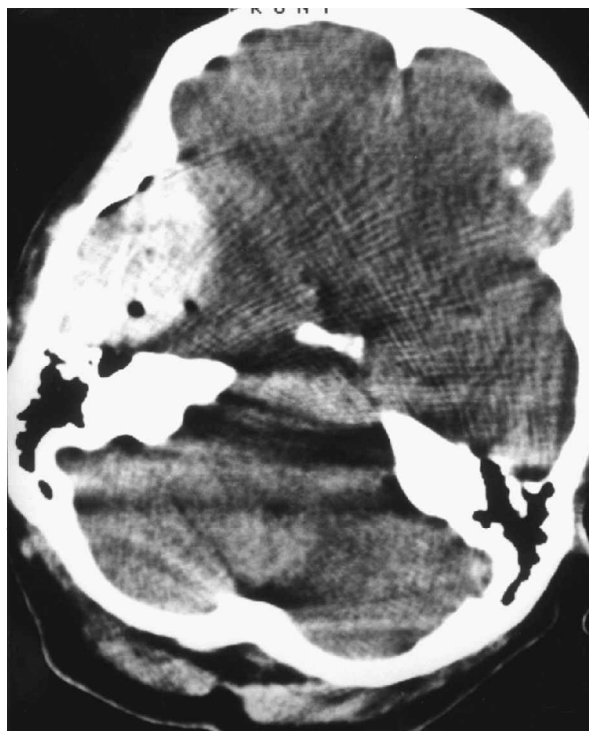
CT showing the patient's left-sided extradural haematoma.
